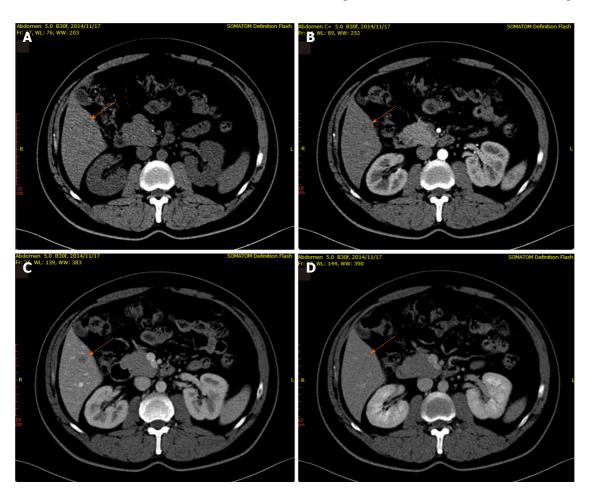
A 46-year-old male patient with focal liver lesions involving the right lobe of the liver. A: Routine computerized tomography (CT) scan revealed an indistinct hypodense lesion (arrow) located in segment V of the liver; B: In the arterial phase, contrast enhanced CT revealed a homogeneous mass with no enhancement (arrow); C and D: A well-defined round mass (arrow), measured about 10 mm × 9 mm, was observed in the portal venous phase (C) and the mass showed iso-density in the delayed phase (D).
